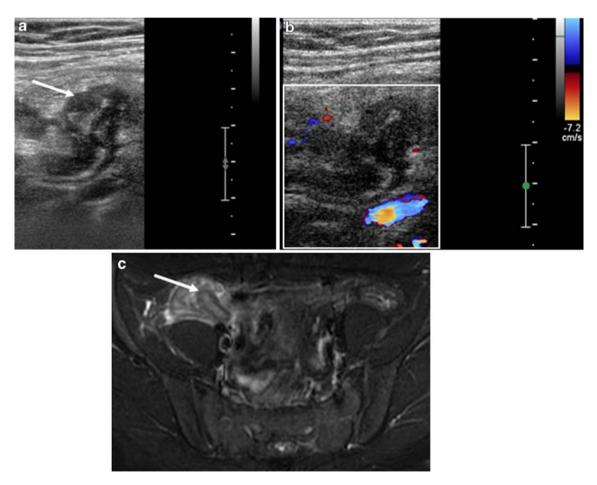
Gray-scale (a) and color Doppler (b) sonograms of a child with acute abdominal pain show a distended appendix, folded on itself, measuring 8 mm at its apex (*arrow*) (a). The tissue surrounding the appendix has increased echogenicity. No definite abscess or free fluid is noted in the right lower quadrant. Mild hyperemia was appreciated within the appendiceal wall at the time of the examination which was
